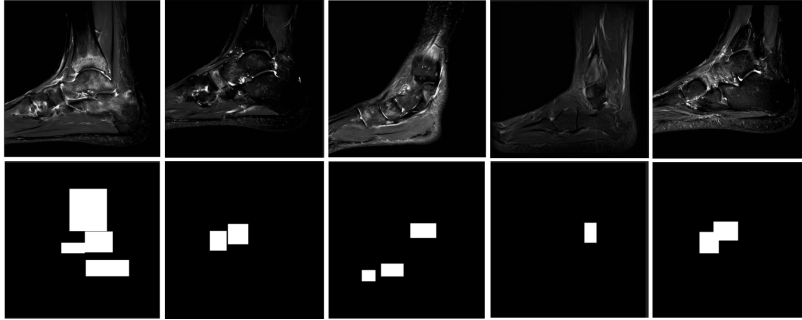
Images and their corresponding masks, highlighting single/multiple regions of interest (ROIs) of edemas in MRI scans with bounding boxes.
